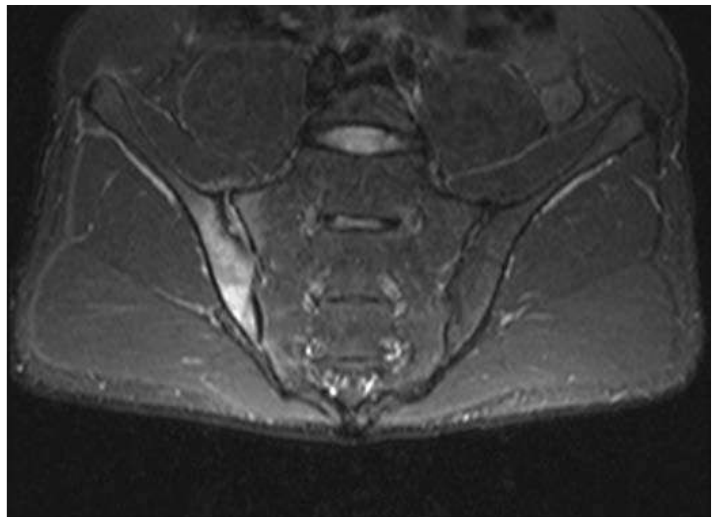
MRI of SIJ: active sacroiliitis shown by the hyperintense signal in the ilium and in the upper part of the sacrum of the right SIJ (Watts RA, et al. Oxford textbook of rheumatology. 2013)
